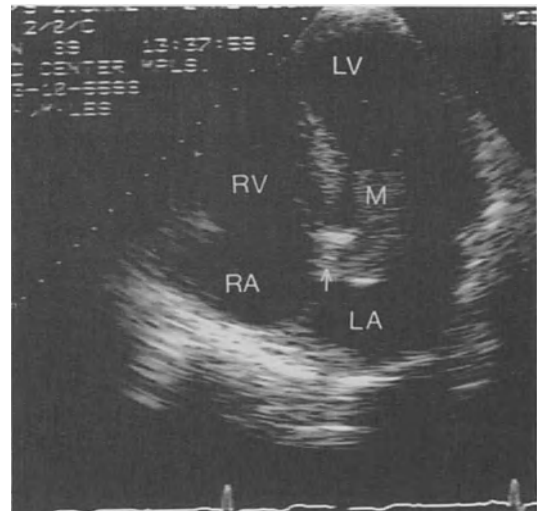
2D echocardiogram, left atrial myxoma (M) prolapsing into the left ventricle. The tumor is attached to the atrial septum (arrow).
